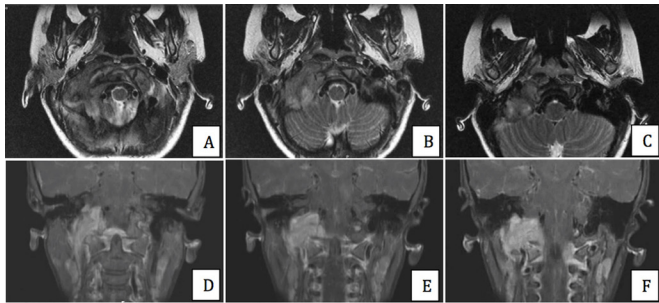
Axial T2-weighted images on MRI (A–C) and coronal T1-weighted images with contrast enhancement (D–F) imaging planes, showing the same lesion in relation with the adjacent structures.
